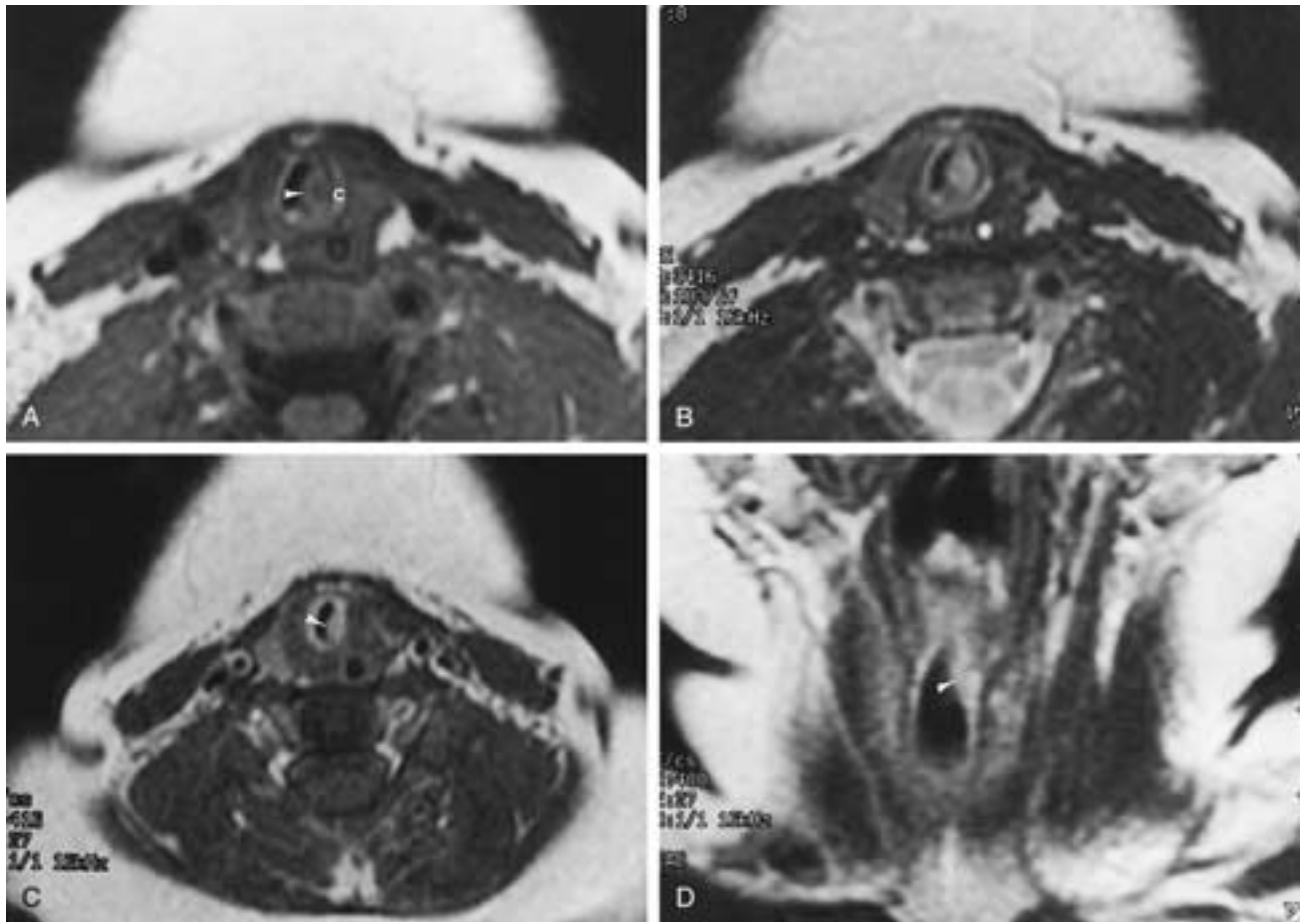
Subglottic hemangioma, MR image. A, Axial T1-weighted image shows a small bulge (*arrowhead*) at the level of the cricoid cartilage. B, T2-weighted image shows high signal in the abnormality characteristic of the hemangioma. C, Postcontrast T1-weighted image shows enhancement of the hemangioma (*arrowhead*) and the mucosa. D, Coronal image shows the enhancing lesion (*arrowhead*) in the subglottic angle. The lesion is limited to the mucosal area.
